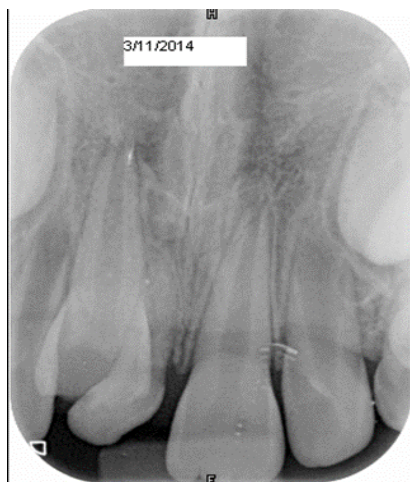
Initial intraoral periapical radiograph showing the intruded right immature maxillary central incisor with uncomplicated crown fracture, diminished and irregular periodontal space and presence of a supernumerary tooth palatally.
